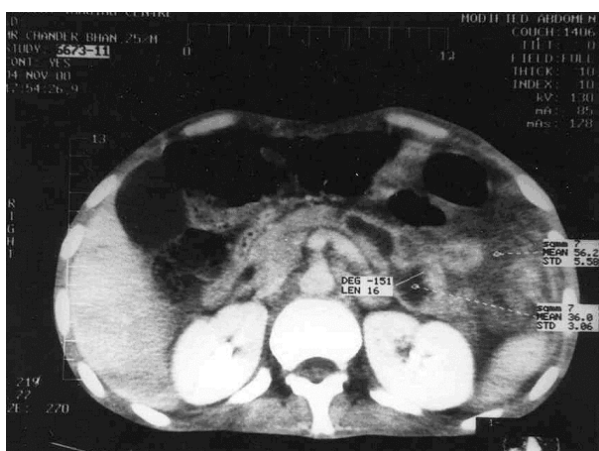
Abdominal CT scan showing acute pancreatitis with focal hypodensities.
